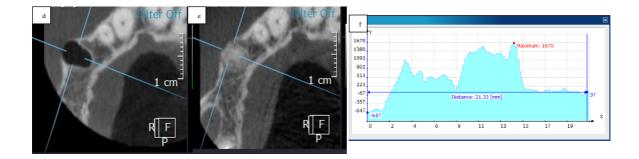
Superimposed CBCT Images demonstrating Alveolar bone change following 4 months healing. (a) primary CBCT image taken after tooth extraction. (b) Secondary CBCT image taken at 4 months healing. (c) Merged primary and secondary CBCT images, visualised using different colour masks. (d) Primary Axial Plane. (e) Secondary Axial Plane. (f) Graph from profile measurement tool, which was used to assess the dimensions of the alveolar ridge along the measurement axis. (*) orange colour represents original bone profile. (^) purple overlay outlines the residual morphology of the alveolar ridge when the secondary CBCT image was taken (4 months).
